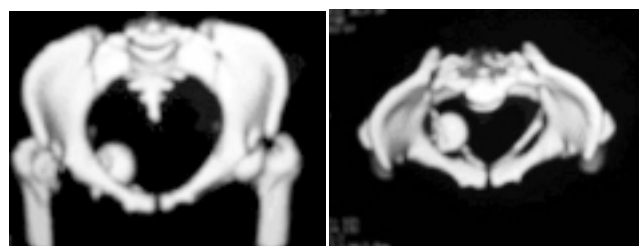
CT Scan showing head into the pelvic cavity.
